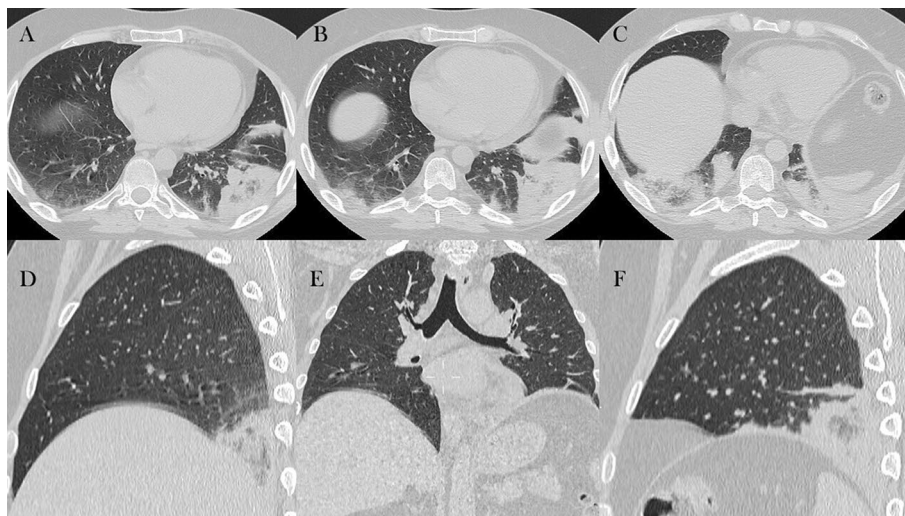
The CT windows of both lungs evaluated entirely in the axial (A, B, and C), sagittal (D and F), and coronal (E) planes do not show other significant parenchymal alterations
